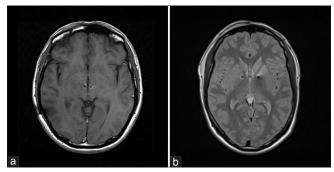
Postoperative brain MRI. (a) DBS leads at the ventro-oralisinternus centromedian parafascicular thalamus (Voi-CM/Pf). (b) DBS leads at the antero-medial globus pallidus internus (a-GPi)
